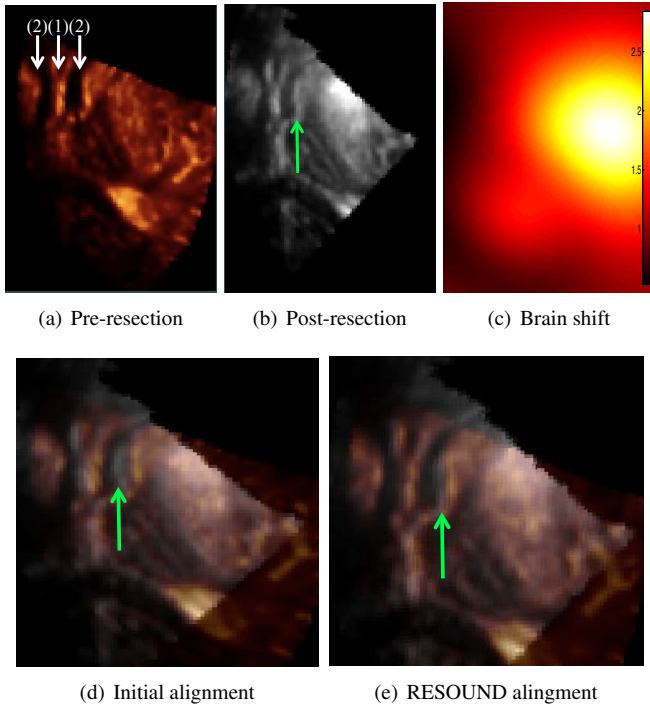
The brain shift in mm, along with the overlaid images before and after registration. Structures (1) and (2) in (a) are respectively the septum and ventricles. Note the misalignment in (d) pointed to by an arrow, which is corrected in (e). The results correspond to patient 13 in Table 1. The tumor and the resection cavity are not present in the shown ultrasound slices. The registration is performed in 3D.
